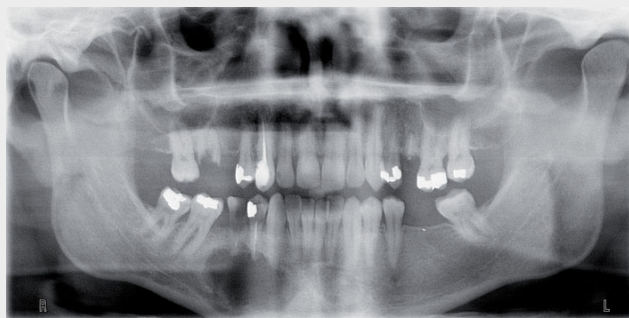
Inicial orthopantomography showed a radiolucent lesion in the 4th quadrant.
